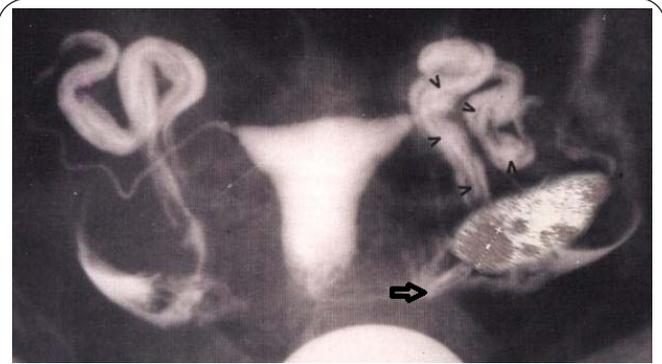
Combined hystero-salpingography and ovarian sonography showing the tubal fimbriae (arrow) surrounding a growing follicle and indicating successful ovum picking. The arrow heads show the site of the tubal cavity.
